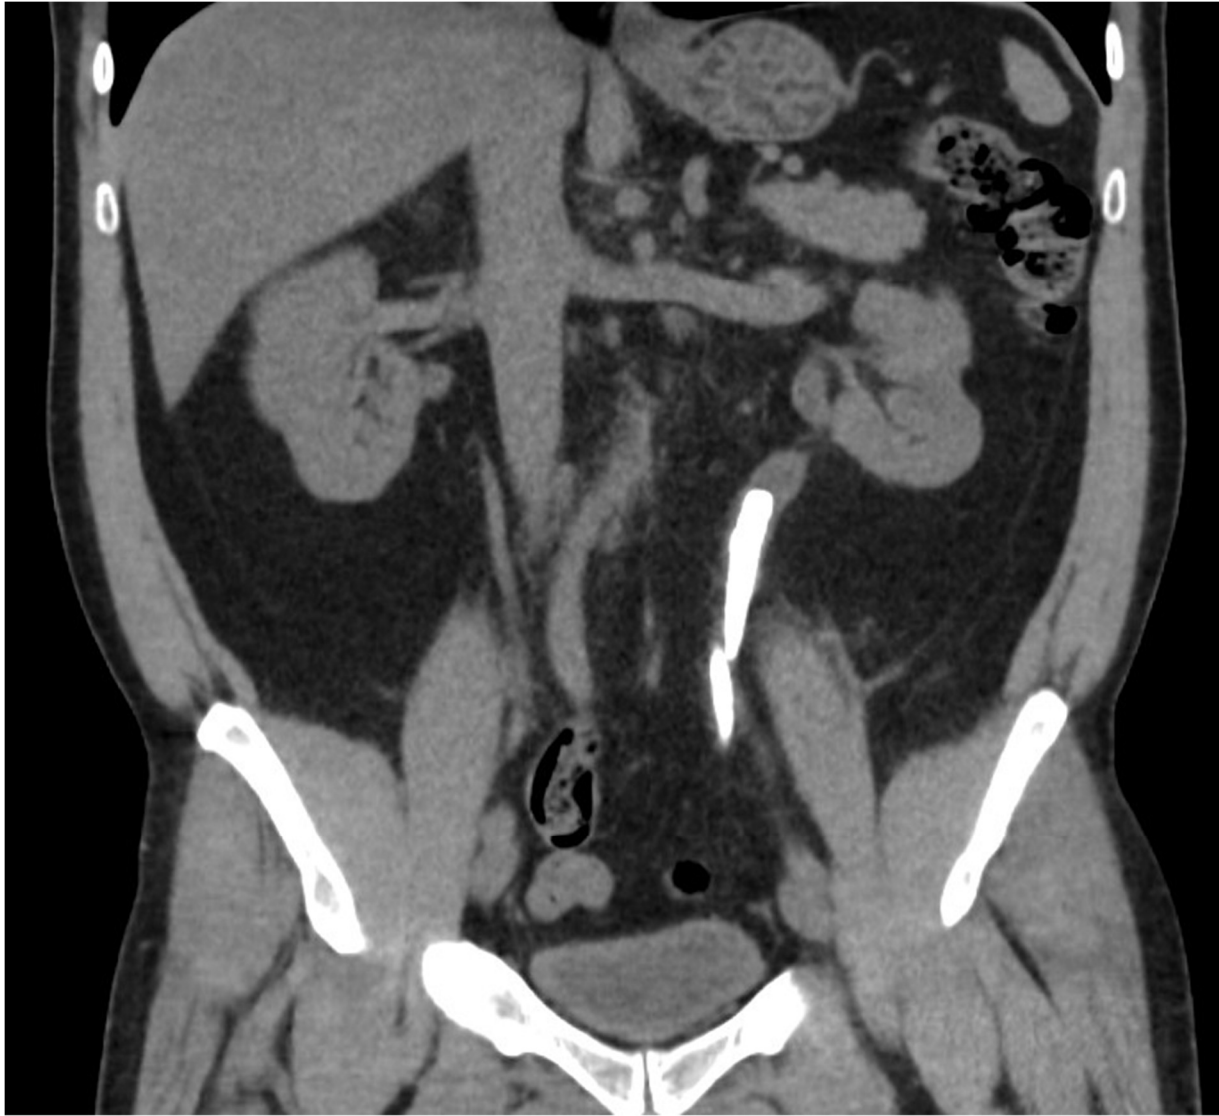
Pre-operative CT of left ureteric stone
